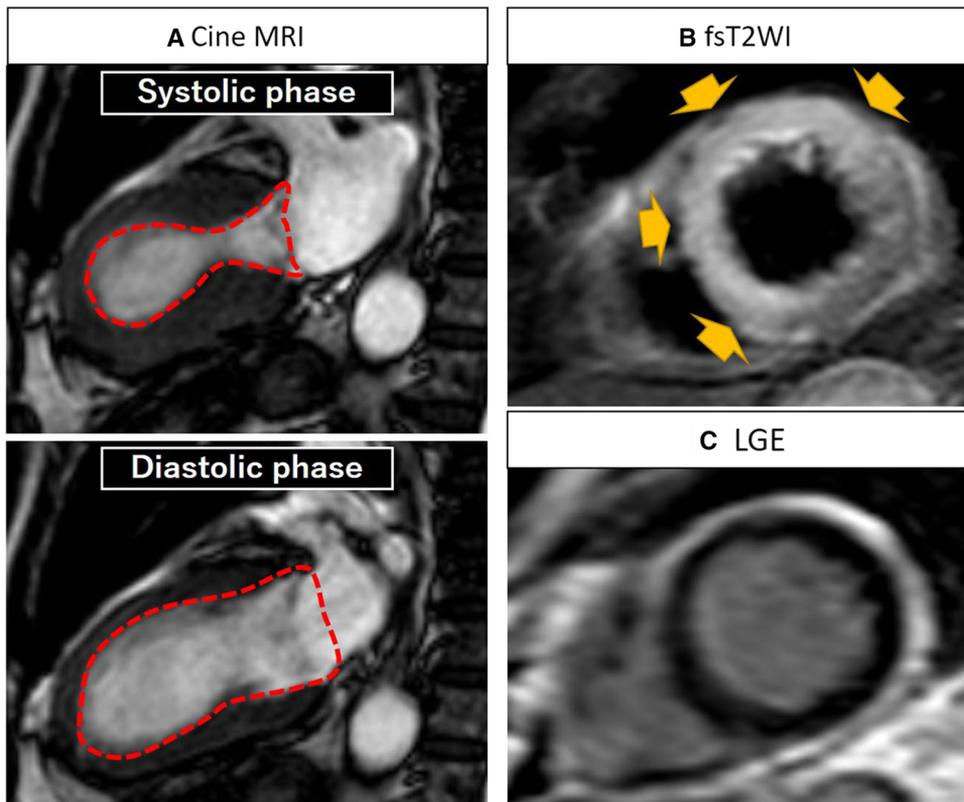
CMR imaging of takotsubo cardiomyopathy. A Wall motion abnormalities at the mid-ventricular to apical anterior segments with cine imaging as apical ballooning. High signal intensity with fat-saturated T2-weighted images (fsT2WI) (yellow arrows) due to the myocardial edema (B), but the absence of the late gadolinium enhancement (LGE) (C) are shown.
